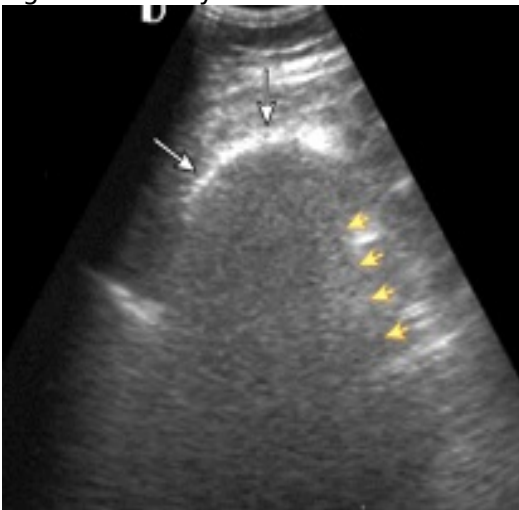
Ultrasound of abdominal cavity, pneumoperitoneum
